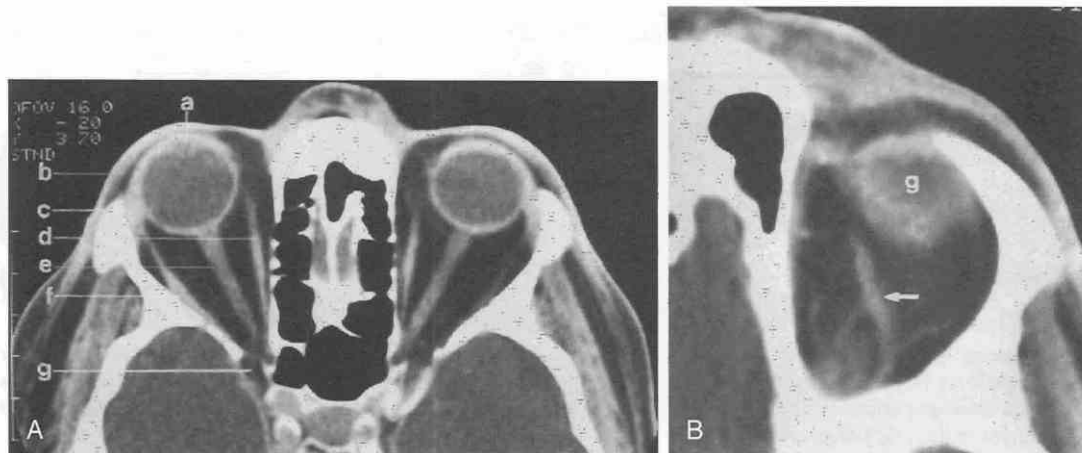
A, Axial CT scan: normal anatomy. Lens (a), lid (b), lacrimal gland (c), medial rectus (d), optic nerve-sheath complex (e), lateral rectus (f), superior orbital fissure (g). B, Axial CT scan: normal anatomy. Superior orbital vein (arrow), globe (g).
